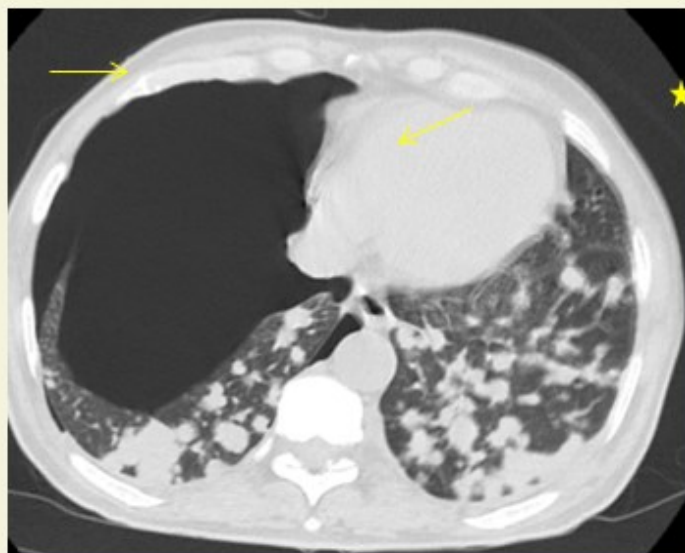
Axial section of CT chest in supine position shows large pneumothorax on the right side (yellow star).
